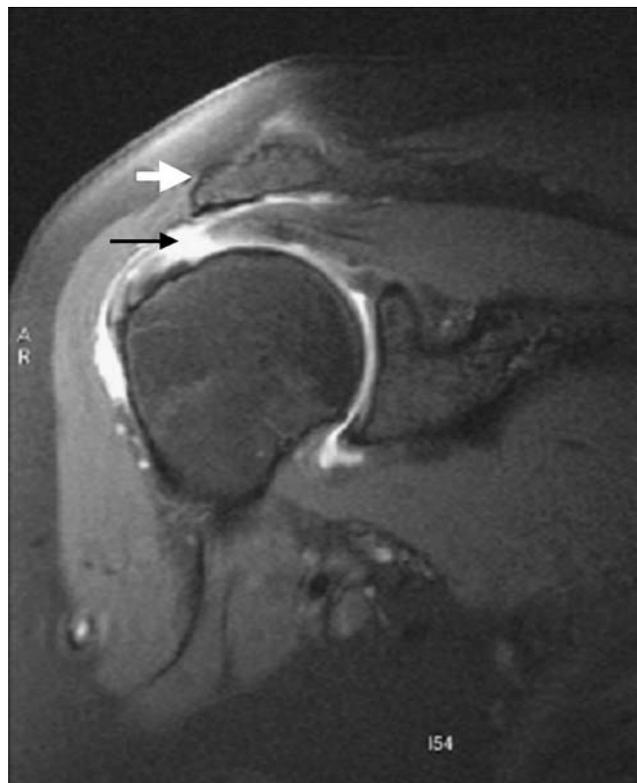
Primary external impingement. Coronal T1-weighted fat-saturated image of a shoulder arthrogram demonstrates a down-sloping acromion (*white arrow*). There is an underlying full-thickness tear of the supraspinatus, approximately 1 cm from the distal insertion, visualized as hyperintense gadolinium extension into the subdeltoid subacromial bursa (*black arrow*)
